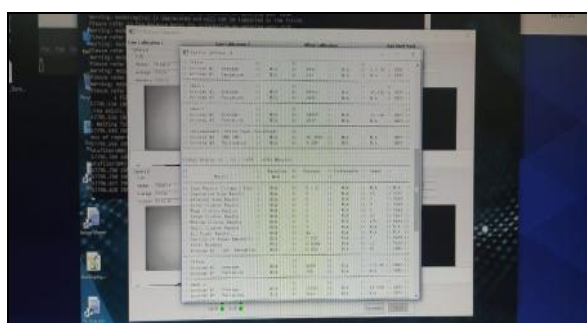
For X-ray tube A
